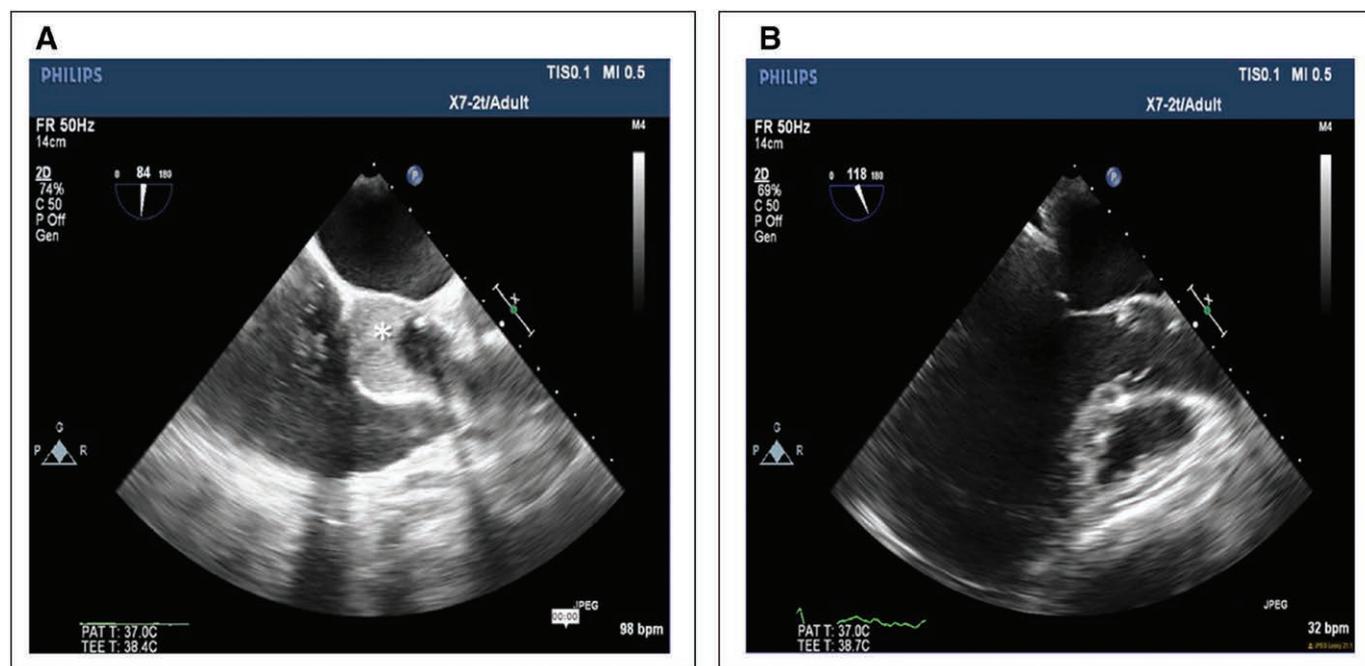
A, Transoesophageal echocardiogram, modified mid-oesophageal short axis view. Echo contrast is seen in the aortic root (*). The aortic valve is not opening throughout the cardiac cycle. B, After inotropic therapy and reduction of veno-arterial extracorporeal membrane oxygenation flow, resumption of systolic aortic valve opening and disappearance of echo contrast were observed within 3 min. bpm = beats/min, G = general, P = penetration (imaging characteristics), PAT = patient, R = resolution, TEE = transoesophageal echocardiography.
